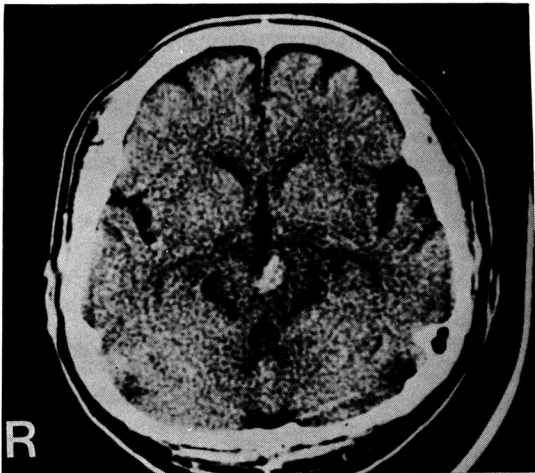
Unenhanced CT reveals a high-density region in the left tegmentum of midbrain adjacent to the posterior third ventricle.
